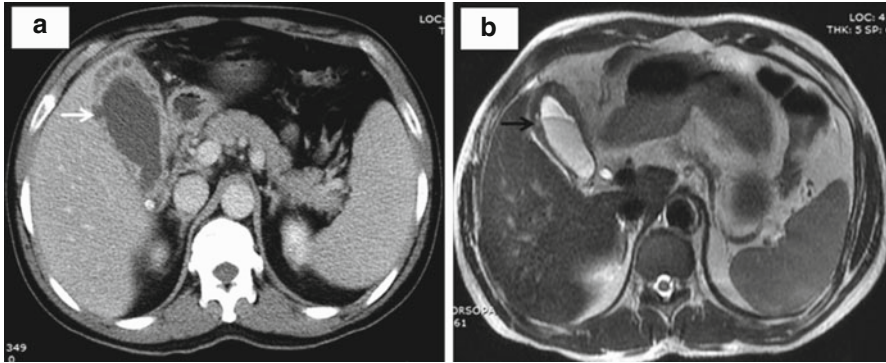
Xanthogranulomatous cholecystitis. Axial contrast enhanced CT image (a) and axial T2-weighted MR image (b) of a 38-year-old lady showing diffusely thickened gallbladder wall containing nodules within the wall. Nodules are hypodense on contrast enhanced CT (*white arrow*) and T2 weighted hyper-intense on MRI (*black arrow*) with continuous mucosal enhancement
